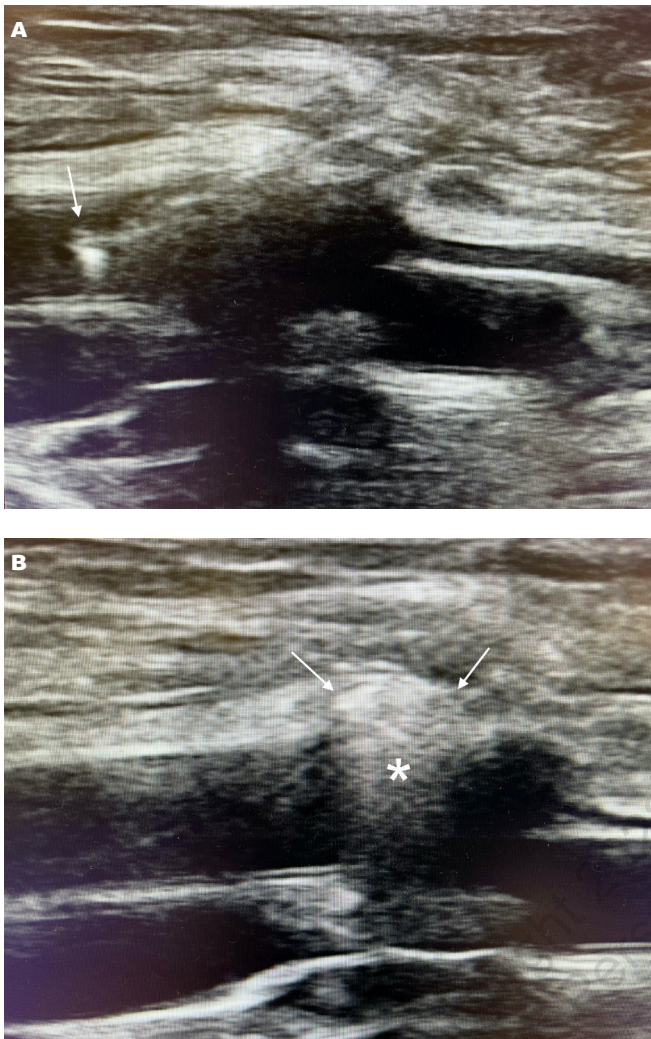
Ultrasound images demonstrating deployment of a Celt ACD device (Vasorum, Ltd). (A) The device has been advanced through the sheath and the endoluminal disc was deployed within the superficial femoral artery. (B) The device has been deployed with the echogenic endoluminal disc closing the arteriotomy.
